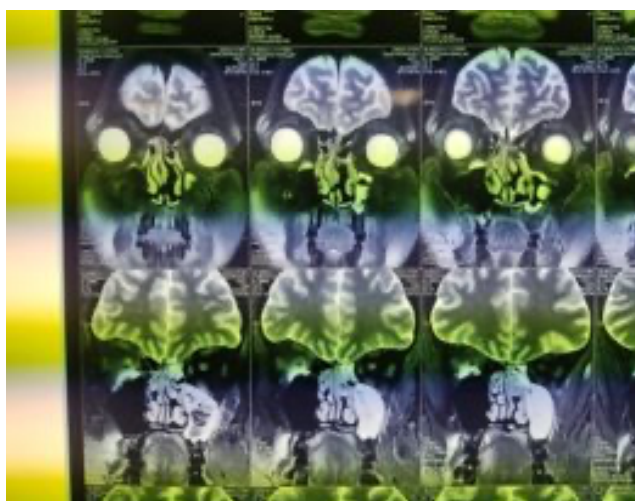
MRI picture, early sinus disease
